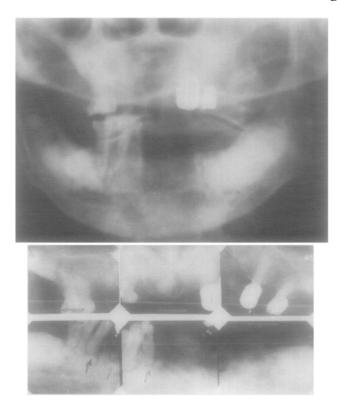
Radiographs taken in 1967, showing the presence of diffuse areas of radiopacity in the mandible.
